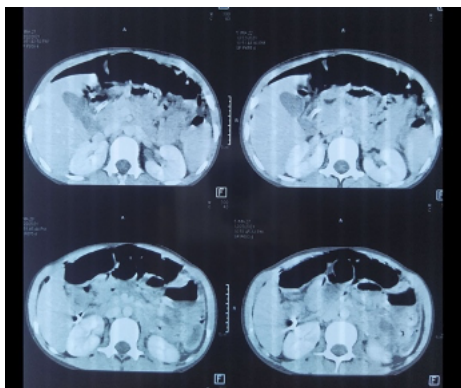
Axial sections of CT abdomen showing no evidence of any foreign body
